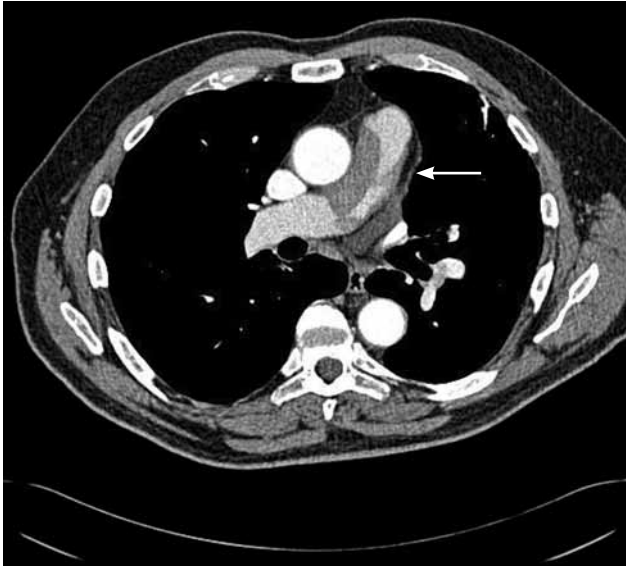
Preoperative computed tomography scan demonstrating the lesion in the main pulmonary artery (arrow).
